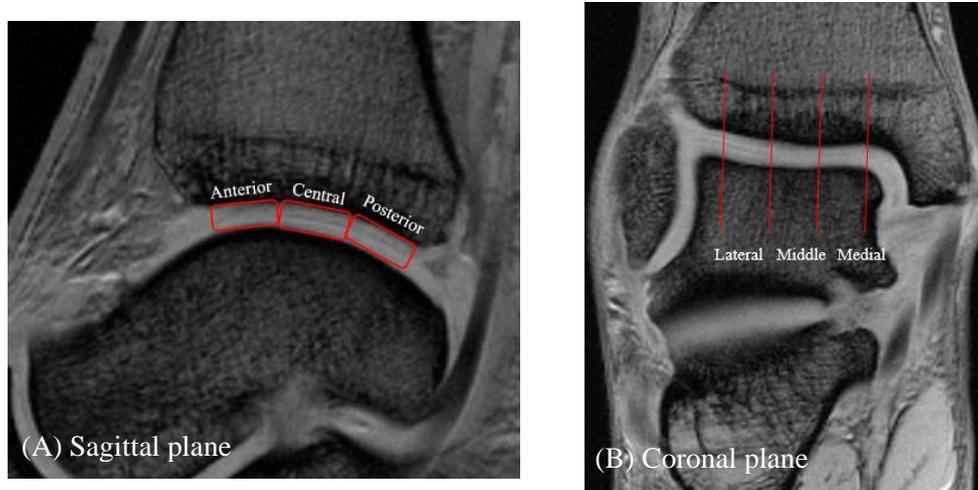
1. Post-processing of MR image for T2 relaxation time of tibiotalar cartilage.
